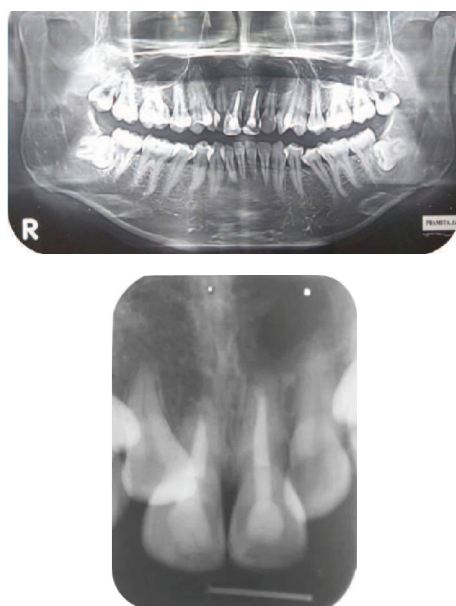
Radiograph examination view on OPG and periapical shows the radiolucen area in apex 21 looks smaller and significant healing on hard tissue
